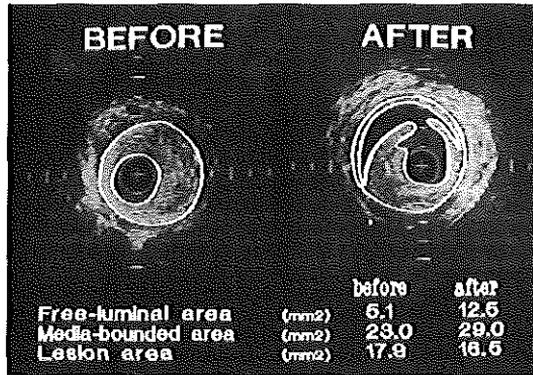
Intravascular ultrasonographic cross sections of superficial femoral artery before and after balloon angioplasty showing traced contours of free lumen and media-bounded lumen area. Region enclosed by two contours is lesion area. Quantitative results before and after intervention are provided. (Reprinted in part with permission of *Circulation* from The SHK, Gussenhoven EJ, Zhong Y, et al. *Circulation* 1992;86:483-93.)
